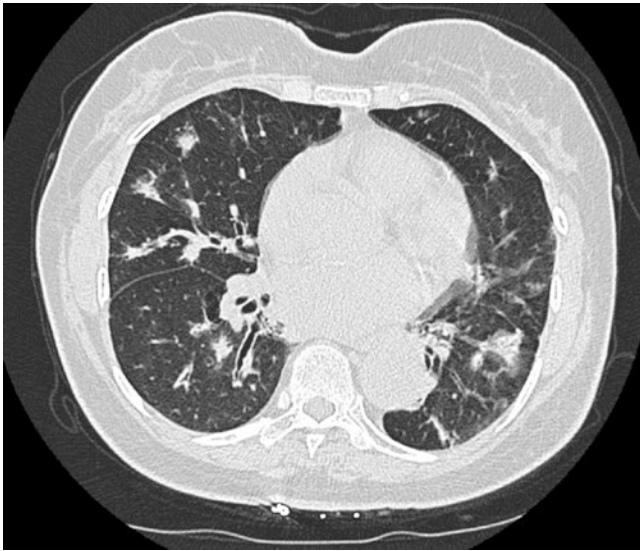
CT scan of the chest demonstrating multiple small bilateral well-defined nodules predominantly in the low lung zones
